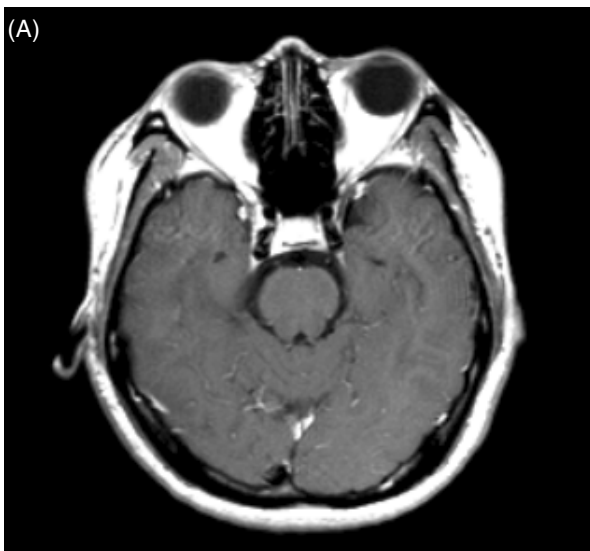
Magnetic resonance imaging of the brain failed to show any abnormality. (A) T1-weighted axial image with Gd enhancement. (B) T2-weighted axial image.
